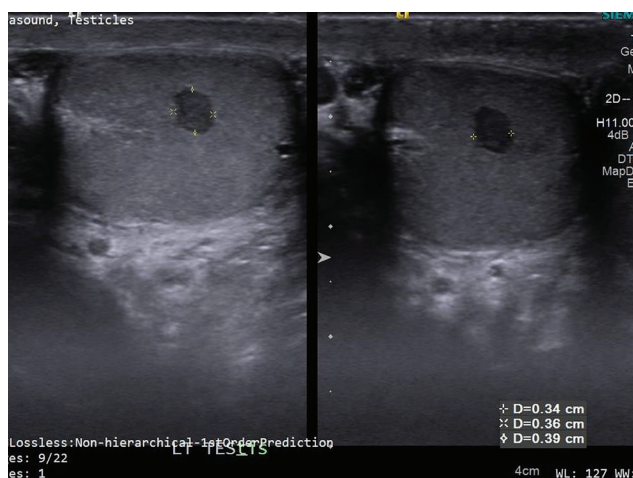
A well-circumscribed round hypoechoic focus with minimal to absent vascularity on scrotal ultrasound measuring 0.34 x 0.36 x 0.39 cm.
